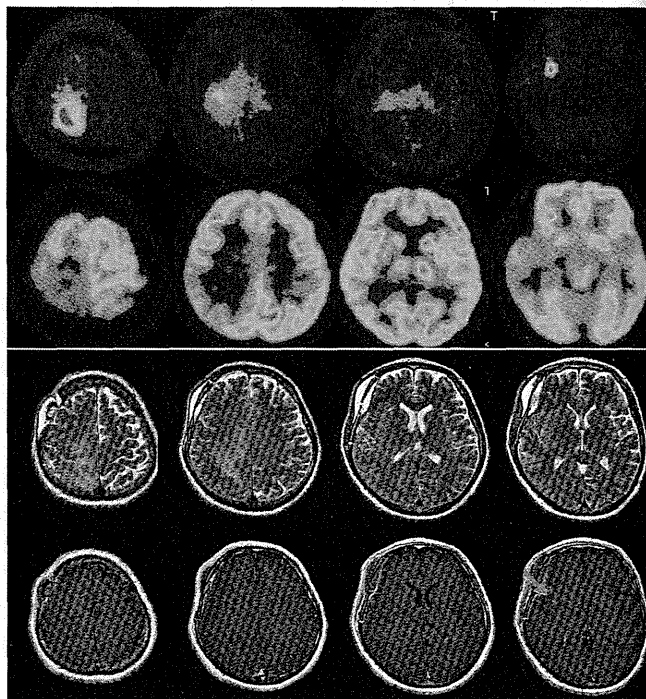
上から MET-PET, FDG-PET, MRI T2WI, Gd 造影 T1WI
